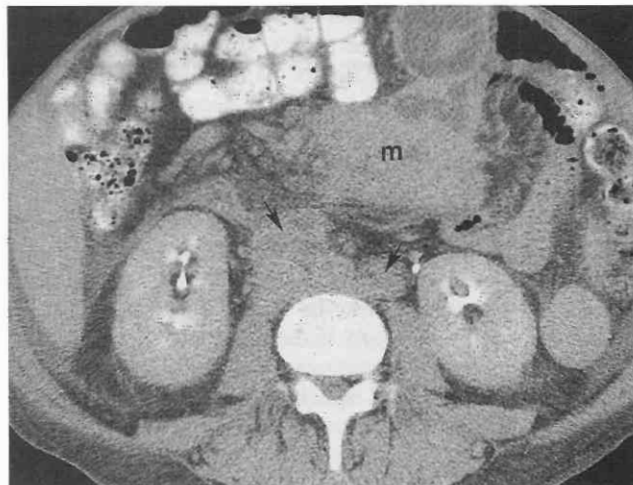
Mycobacterium avium*–*intracellulare* in a patient with human immunodeficiency virus (HIV) infection and a low CD4⁺ count. Enlarged para-aortic and paracaval lymph nodes (arrows) along with a large mesenteric mass (m) are identified on this CT nondynamically enhanced scan. The lymph nodes show characteristic soft tissue attenuation. Low-attenuation lymph nodes are more commonly seen in patients with tuberculosis.
